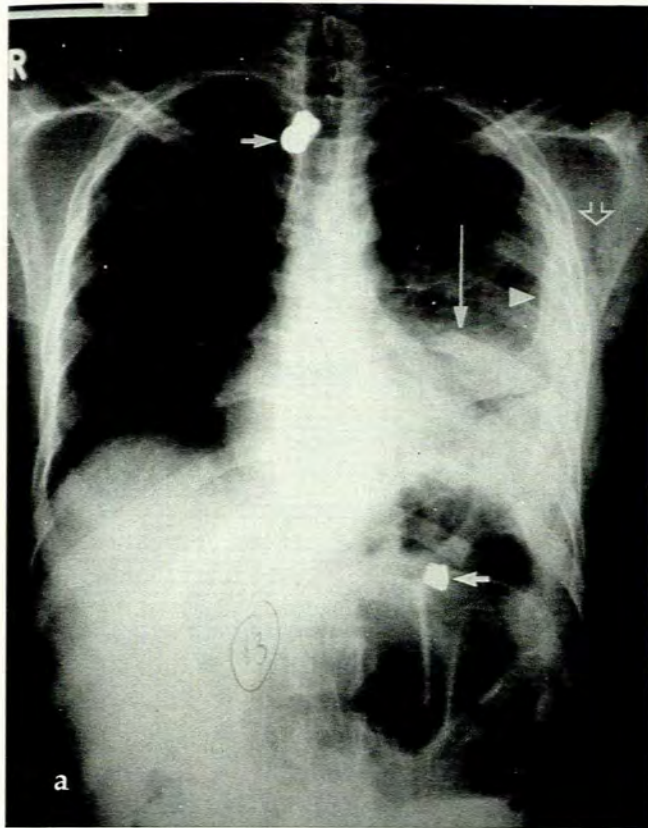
Conventional (a) and digital (b) radiographs of a patient following a gunshot wound, showing bullets (short arrows), pleural fluid (arrowhead), lung opacification (long arrow) and surgical emphysema (open arrow). Vertical linear bands are due to a 'butting' artefact arising from the method of detector construction.
